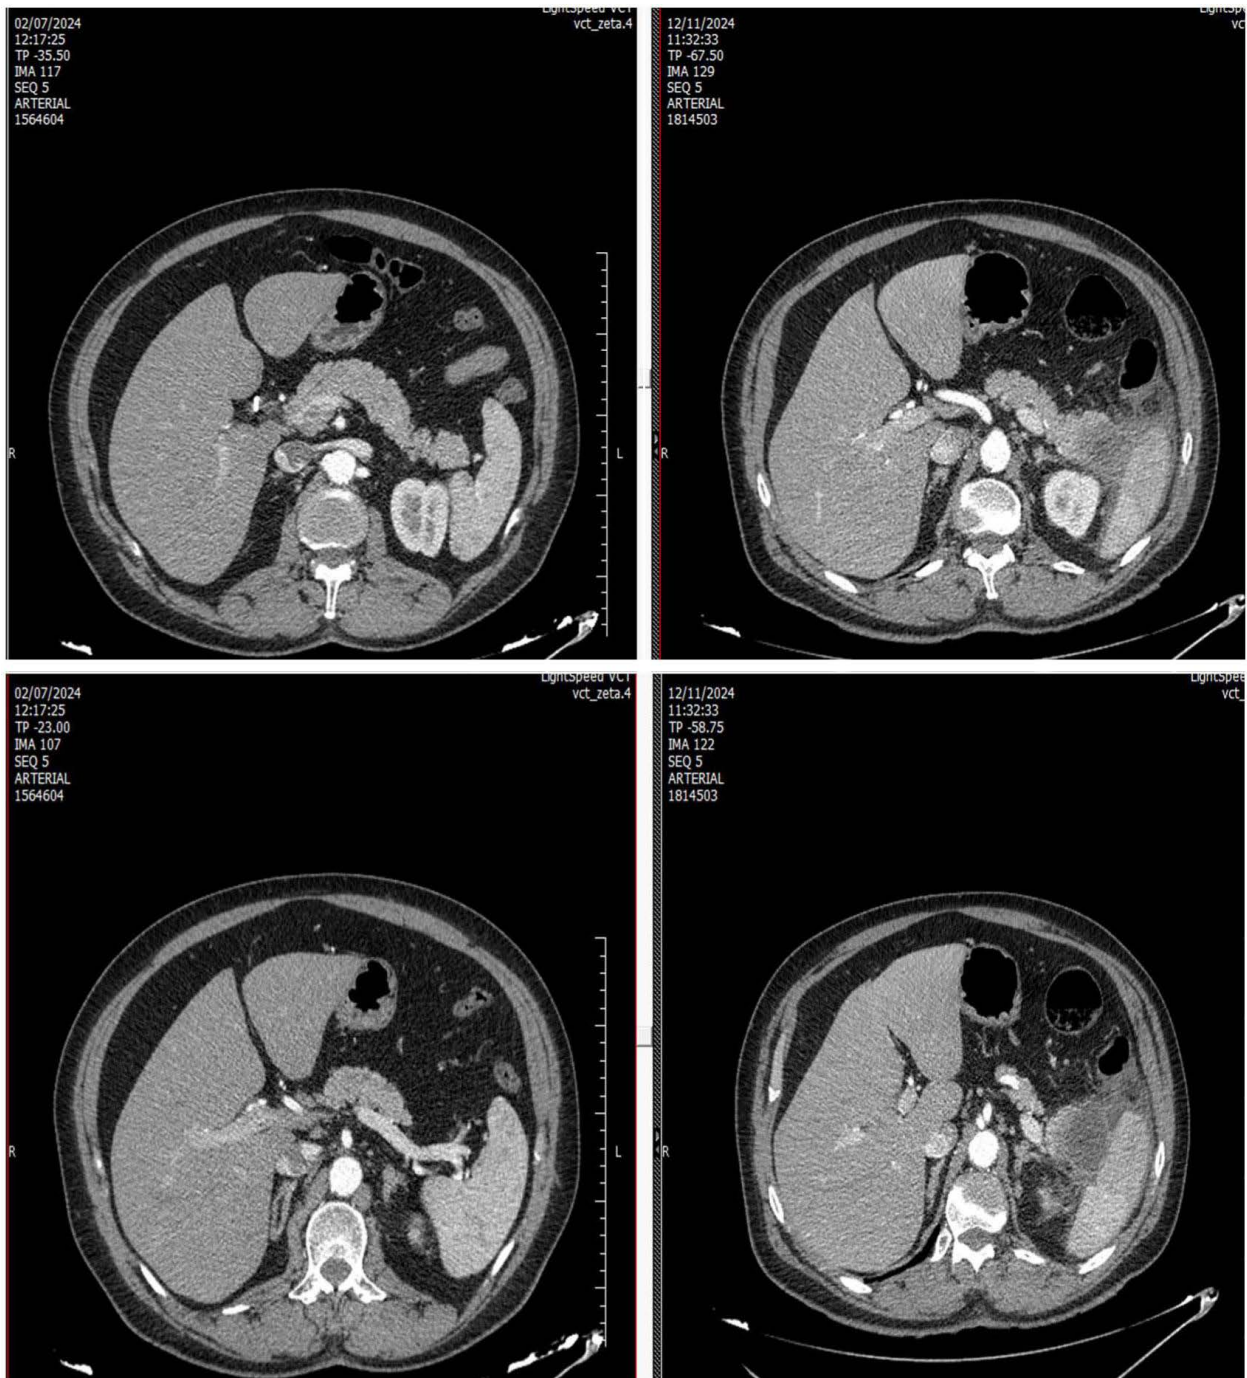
High-resolution computerized tomography (CT) scans done during hospitalization. To the left, the image from July/24 and to the right, the image from November/24. Images obtained on arterial phase. In November 2024, a necrotic lesion of the pancreatic tail was noted, along with a heterogeneous-appearing spleen bordered by fluid and thickening of adjacent fats not previously observed in an imaging examination performed in July
